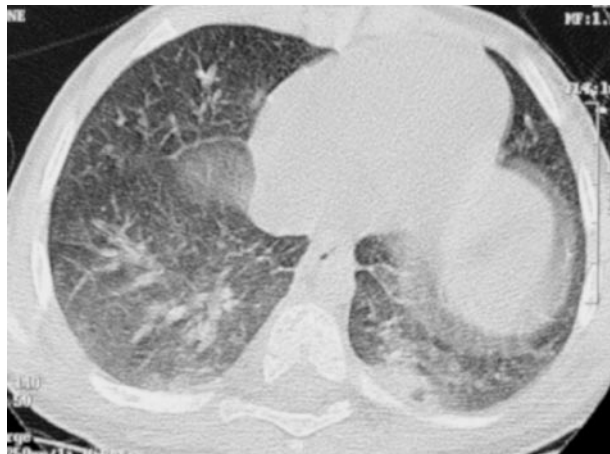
Follow-up computed tomography scan of the thorax demonstrating bilateral lower lobe pneumonia with cavitation of the left side.
